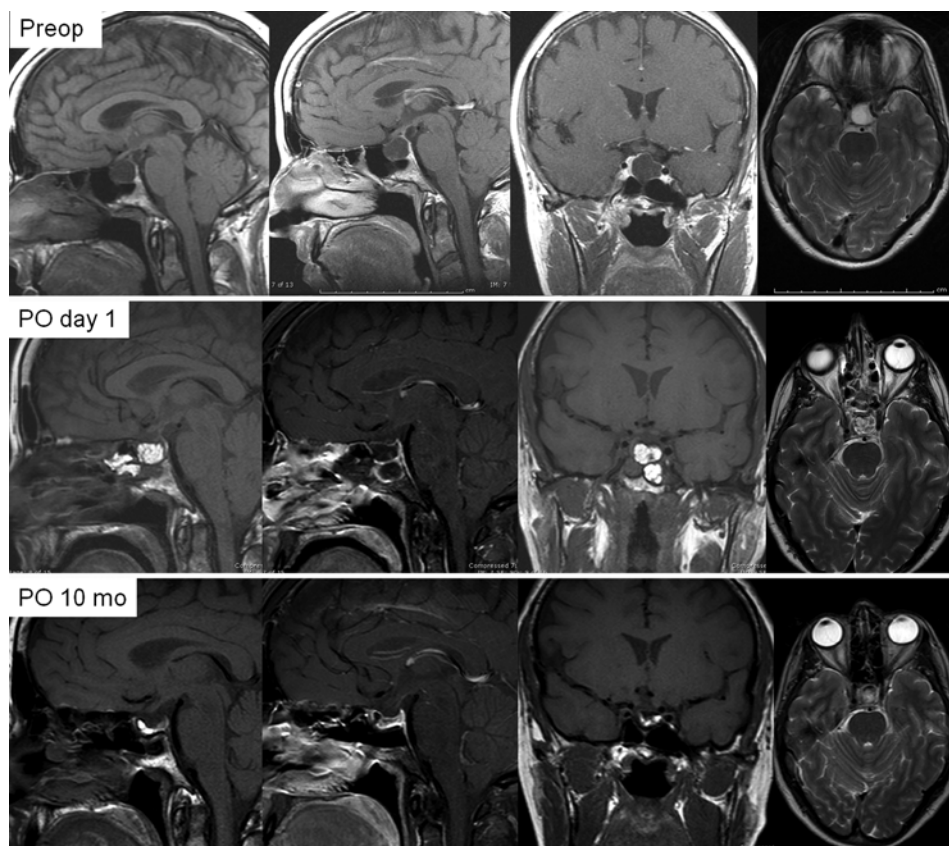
Case 8. Preoperative MR imaging (*upper row*; sagittal, sagittal, coronal, and axial orientations from left to right) showing a cystic sellar lesion with suprasellar extension measuring $14 \times 16 \times 17$ mm following CSF signal intensity on all sequences. The gland was thinned and pushed toward the right, as was the pituitary stalk. Postoperative (PO) Day 1 MR imaging (*center row*) showing cyst drainage and obliteration with fat, and skull base reconstruction. At 10 months after surgery (*lower row*), MR imaging shows continued collapse of the AC with minimal residual fat graft and thicker pituitary gland.
